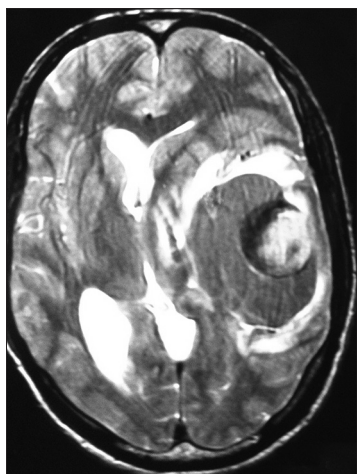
Magnetic resonance imaging brain T2-weighted axial image showing a large lesion with varying intensities in the left posterior frontal region with mass effect and midline shift. The biopsy of the lesion was confirmed as cavernoma
